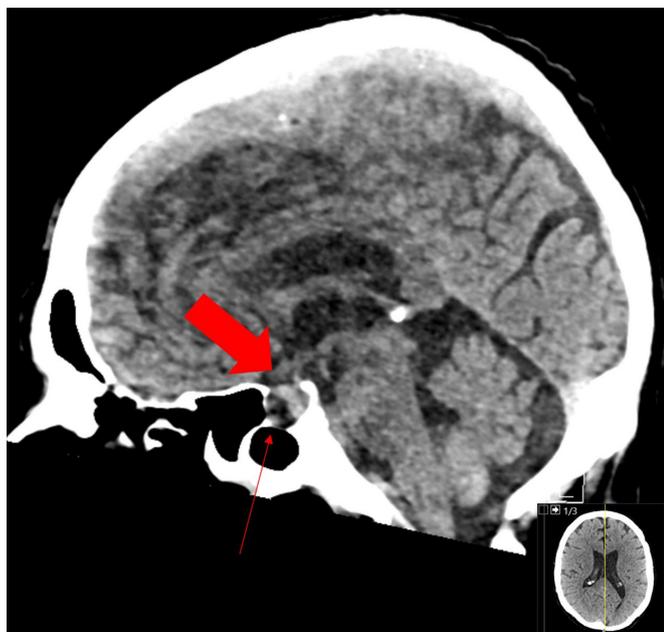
Sagittal reformat of CT scan showing high attenuation mass in pituitary fossa (large arrow). Note that a low attenuation artefact due to beam hardening from adjacent bone obscures the anteroinferior portion of the pituitary fossa (small arrow).
